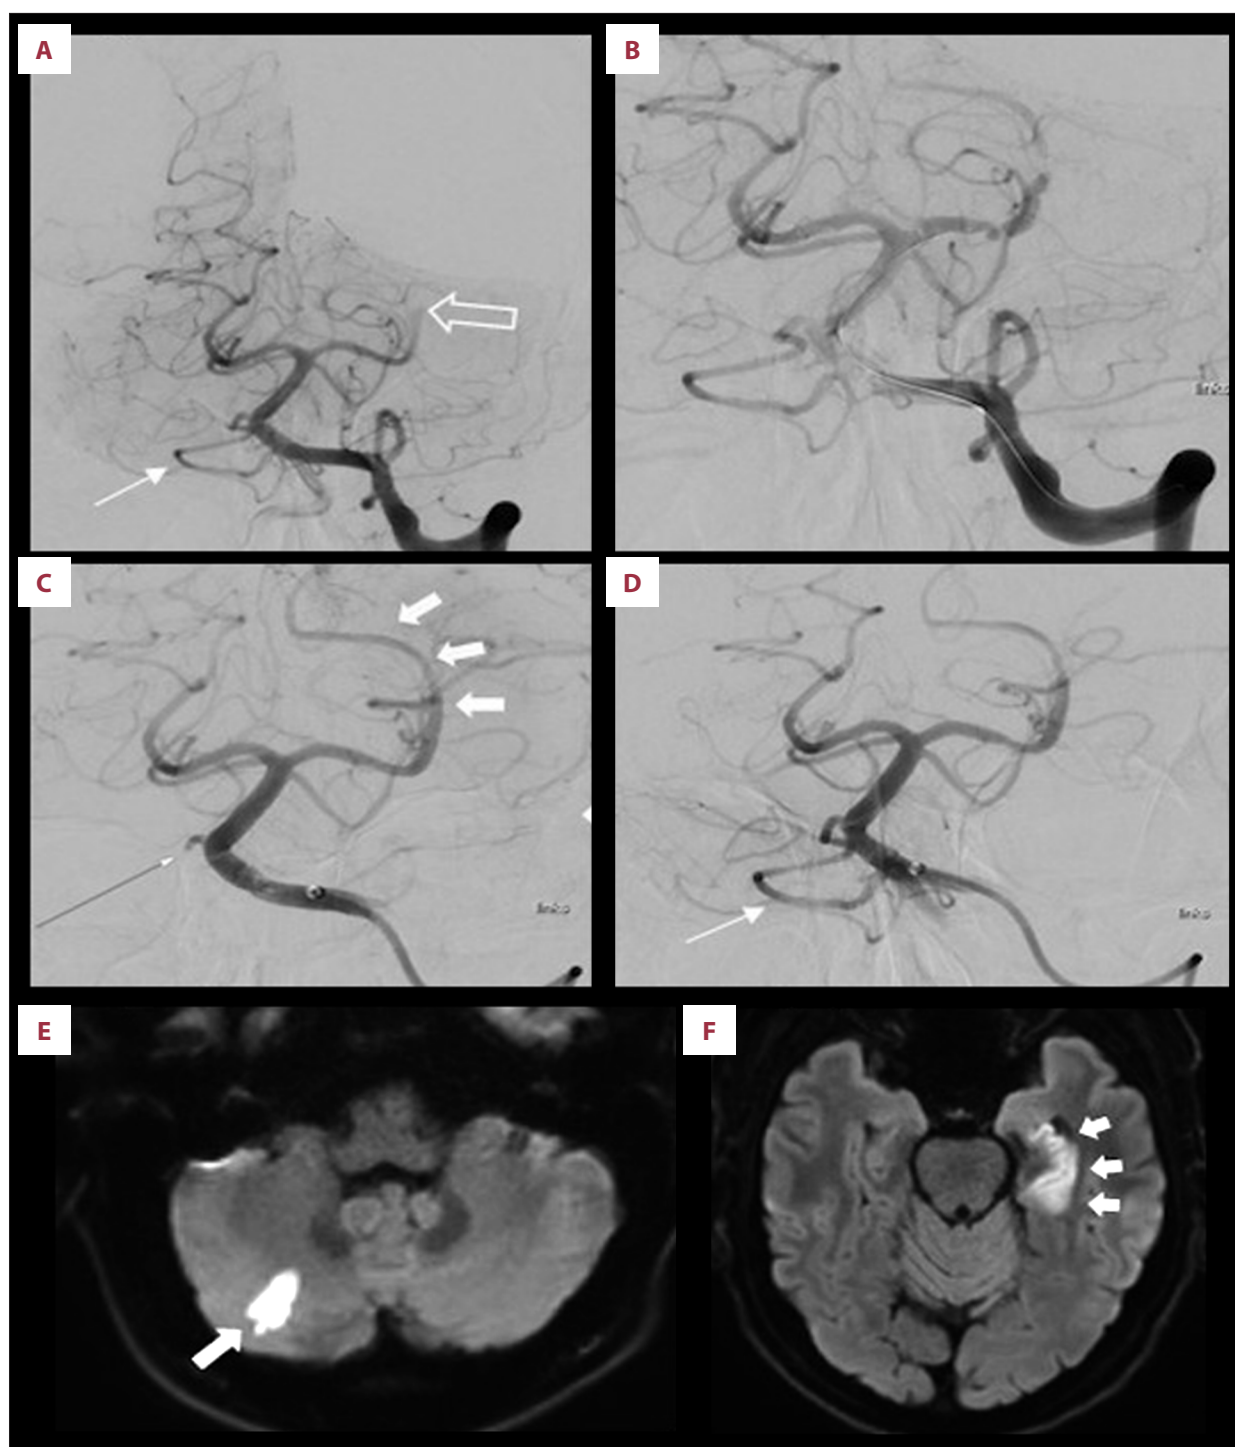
Digital Subtraction Angiography (DSA) and 24-hour control MRI in the Same Patient. DSA showing occlusion of the left posterior cerebral artery (PCA) in the P2 segment (empty arrow) with patent right posterior inferior cerebellar artery (PICA) (thin arrow) (A), with positioned stent retriever from the left P1 to the P2 segment (B). DSA showing complete recanalization of the PCA (thick arrows) and occlusion of the common origin of the right PICA and anterior inferior cerebellar artery (AICA) (thin arrow) due to partial thrombus dislocation (C). Post-procedural DSA showing complete reperfusion of the PICA and AICA (arrow) (D). 24-hour diffusion weighted imaging (DWI) showing a new subacute small cerebellar ischemia (arrow) in the right PICA territory (E) and 24-hour fluid-attenuated inversion recover (FLAIR) images showing the known left hippocampal infarction (arrows) (F).
